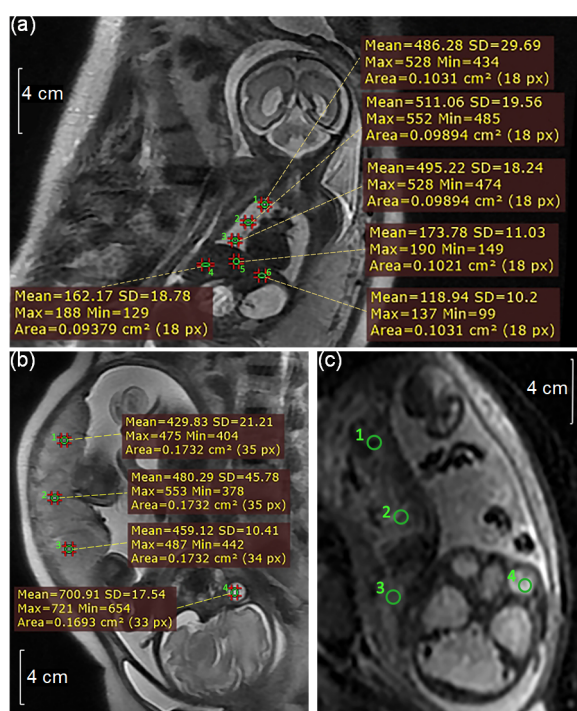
MRI slices showing ROIs
